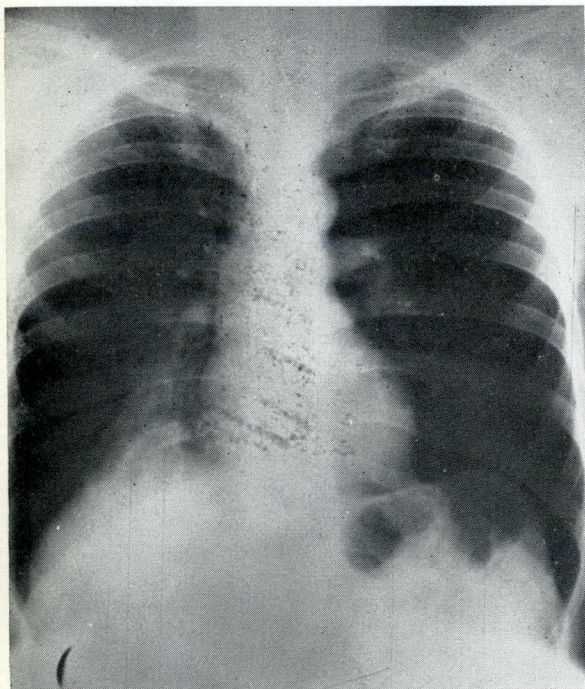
Routine radiograph showing lesion in right costophrenic region.
